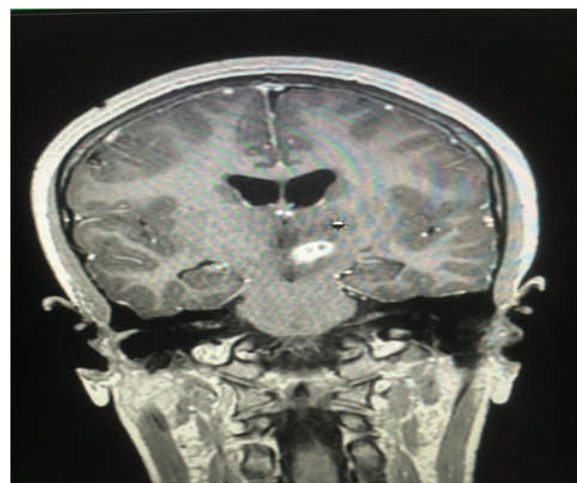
MRI showing single enhancing lesion measuring 17×12×9 mm involving left hypothalamus and midbrain with peri lesional edema
